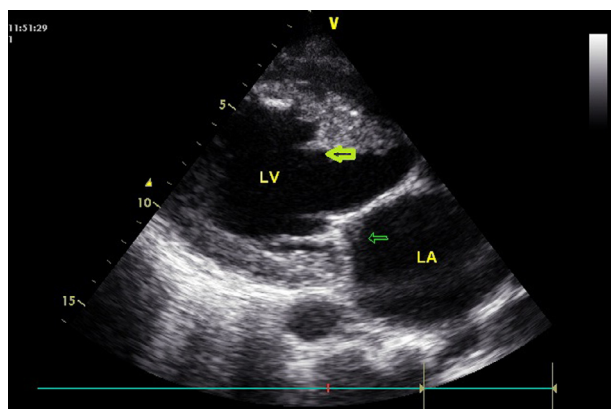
Transesophageal echocardiogram showing vegetation on the atrial side of the mitral valve and left ventricular outflow tract. LA = left atrium; LV = left ventricle.
